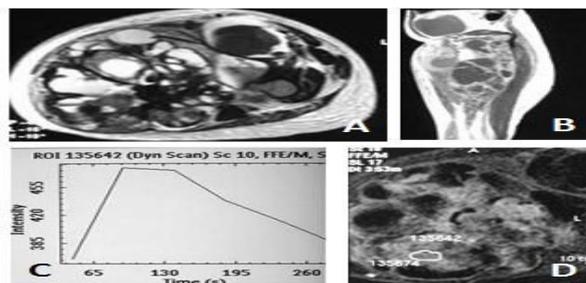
20-year-old woman with a synovial sarcoma. Axial T2-weighted MR image (A) shows heterogeneous, hyperintense, ill-defined mass with including necrotic areas. Static sagittal contrast-enhanced T1-weighted MR image (B) shows heterogeneous enhanced mass Type 3 time-signal intensity curve (C) generated by using ROI on dynamic contrast-enhanced images (D).
